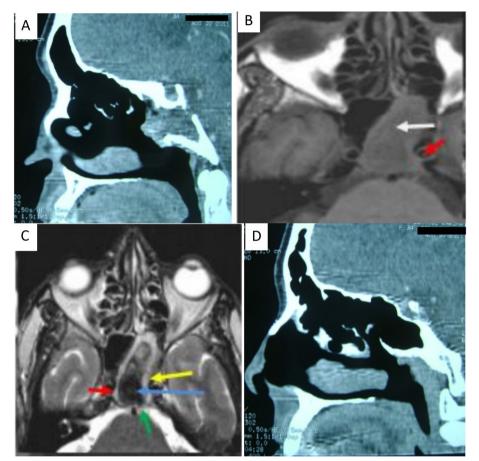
Case 5. Pseudotumoral invasive sinusitis. CT scan sagittal view (A upper left) showing total tissue filling of the sphenoidal sinus with clivus partial destruction. MRI T1-weighted sequence axial view (B upper right) showing an intermediate T1 signal total filling of the left sphenoid sinus (white arrow). MRI T2-weighted sequence axial view (C lower left) showing a hyposignal total filling of the left sphenoid sinus (blue arrow) that encounters close contact with the internal carotid artery (red arrow), basilar trunk (green arrow), and an inflammatory mucosa (yellow arrow), all for a pseudotumoral invasive sinusitis. Postoperative CT scan sagittal view (D lower right) showing a complete removal of the sphenoid sinus pathology
